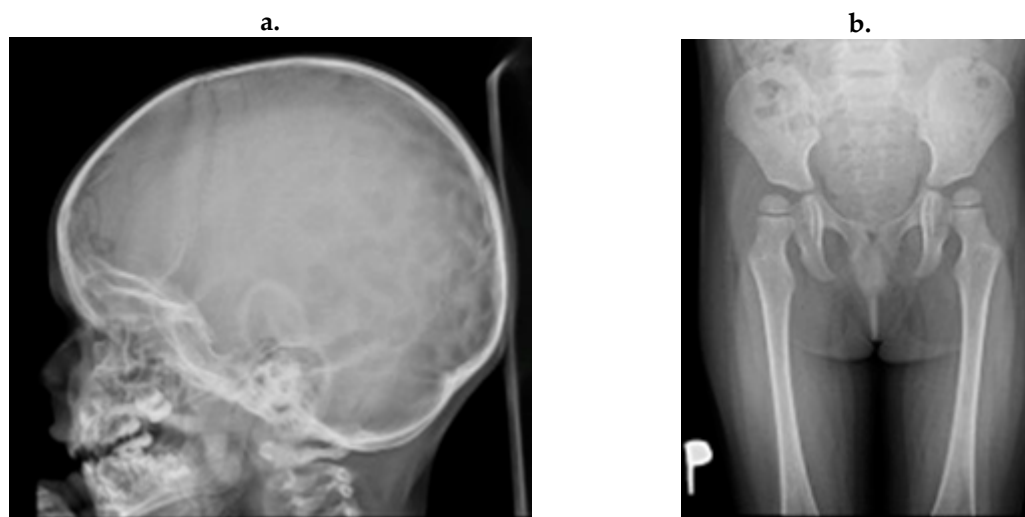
Skeletal X-ray at the age of 19 months: 2a. J-shaped sella turcica, 2b. bilateral coxa valga with signs of hip joint subluxation.
